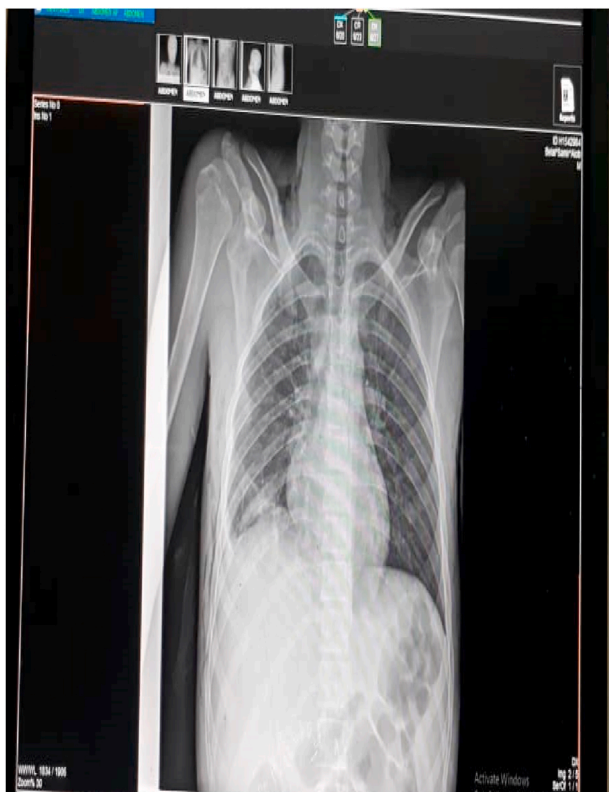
Chest x-ray of the patient in the discharge day.
